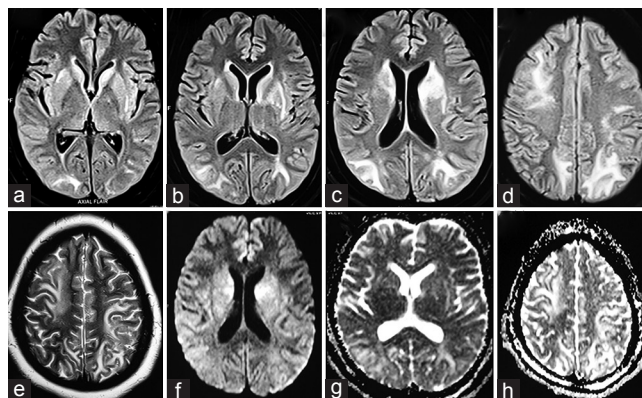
Immediate postpartum MRI. (a-d) Axial FLAIR MRI of the brain showing multiple hyperintensities in bilateral gangliocapsular regions (L>R) and white matter. (e) T2-weighted image showing white matter hyperintensities. (f) DWI and (g,h) apparent diffusion coefficient (ADC) images showing diffusion facilitation
